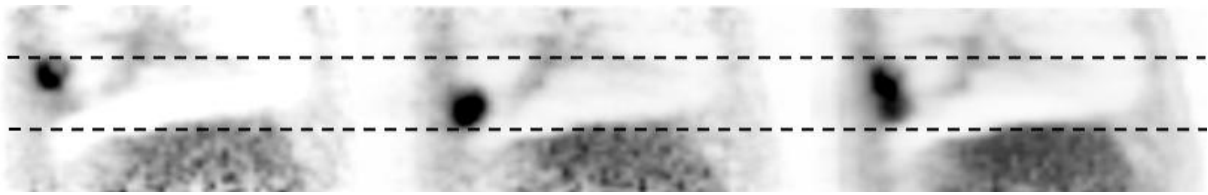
Effect of respiratory motion on PET data from a patient with an FDG-avid lung tumor (sagittal images). On the left, image acquired at the expiratory phase. On the middle, image acquired at inspiration. On the right, static image showing the average of all respiratory phases, as it is usually acquired. The image blurring produced by the respiratory motion results in degraded diagnostic value: the tumor volume is usually overestimated and its maximum metabolic activity underestimated, since the tracer uptake appears distributed over a larger volume. (Image courtesy of Ralph Bundschuh)
